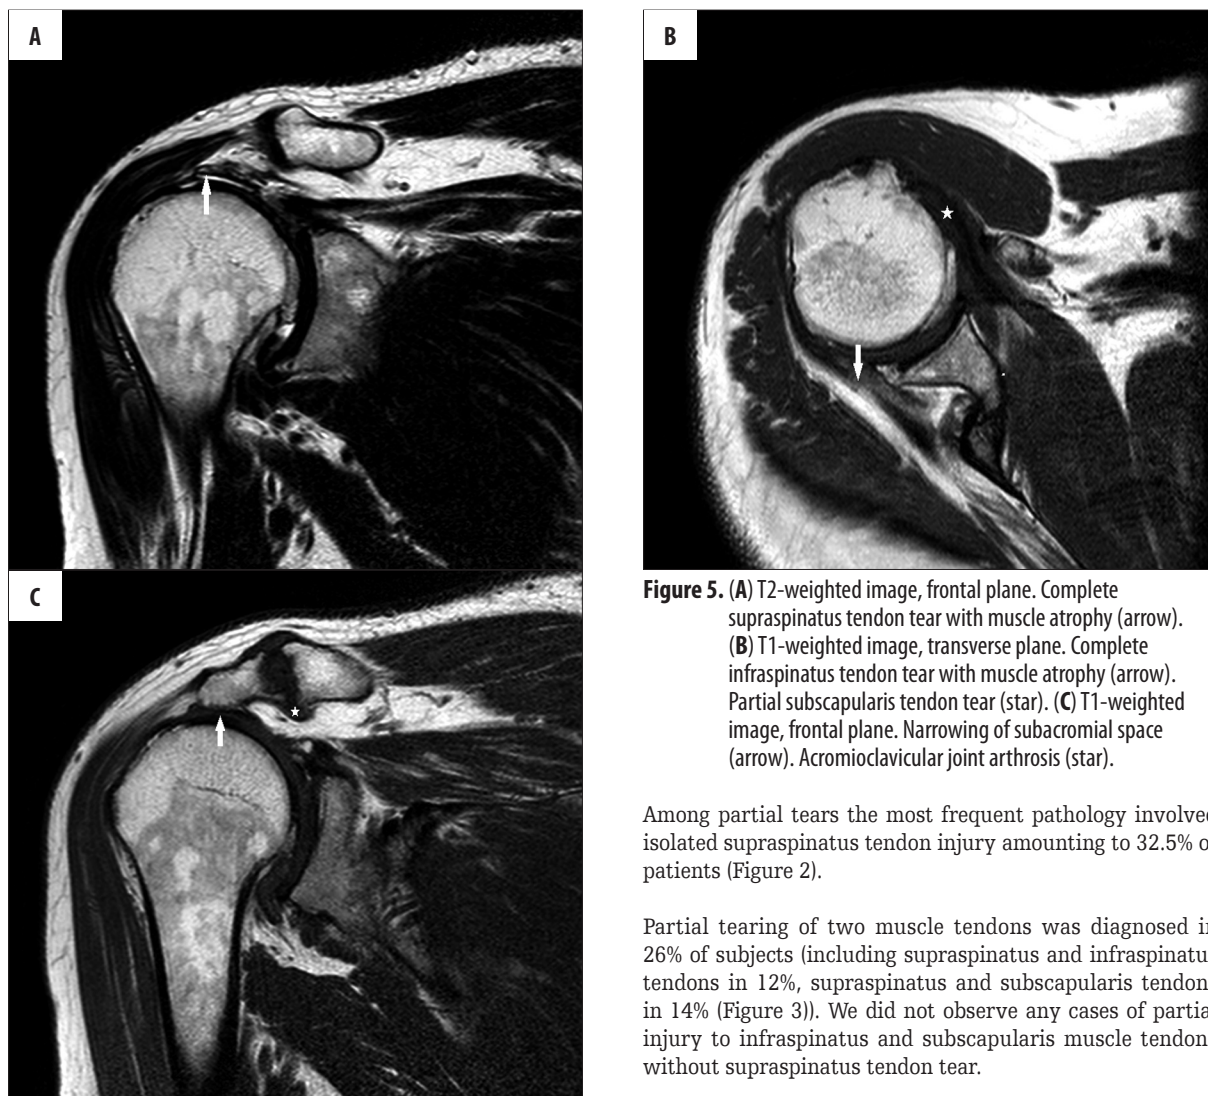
(A) T2-weighted image, frontal plane. Complete supraspinatus tendon tear with muscle atrophy (arrow). (B) T1-weighted image, transverse plane. Complete infraspinatus tendon tear with muscle atrophy (arrow). Partial subscapularis tendon tear (star). (C) T1-weighted image, frontal plane. Narrowing of subacromial space (arrow). Acromioclavicular joint arthrosis (star).
